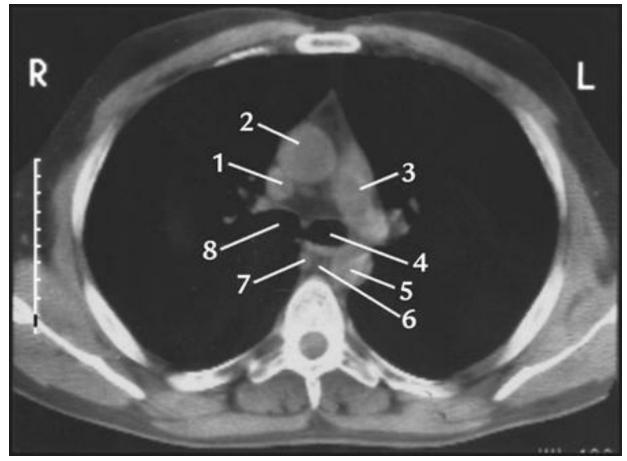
■ CT scan at T5 vertebral level. Just below the tracheal bifurcation, viewed from below: 1 = superior vena cava; 2 = ascending aorta; 3 = left pulmonary artery; 4 = left main bronchus; 5 = thoracic aorta; 6 = oesophagus; 7 = azygos vein; 8 = right main bronchus. (*Source: Last's Anatomy: Regional and Applied*, 12 ed.: Chummy S. Sinnatamby, Fig. 4.14, Page 194, Churchill Livingstone (Elsevier), 2011.)
